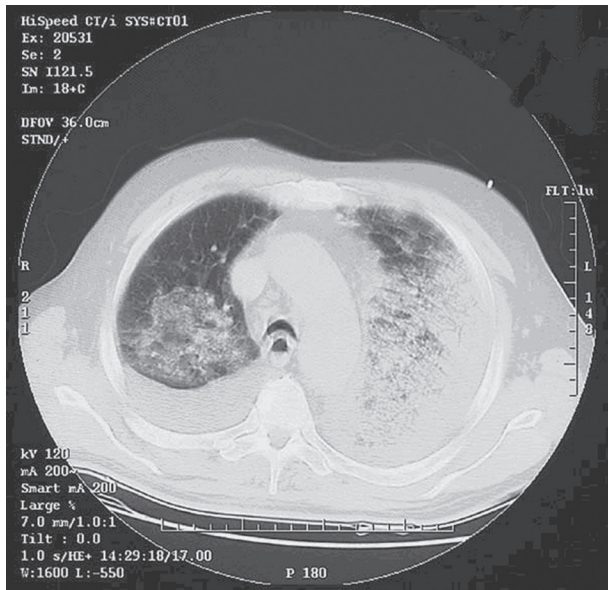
Chest computed tomography (CT) scan of an anthrax patient showing pulmonary consolidation and effusions. (Courtesy Centers for Disease Control and Prevention [CDC].)
